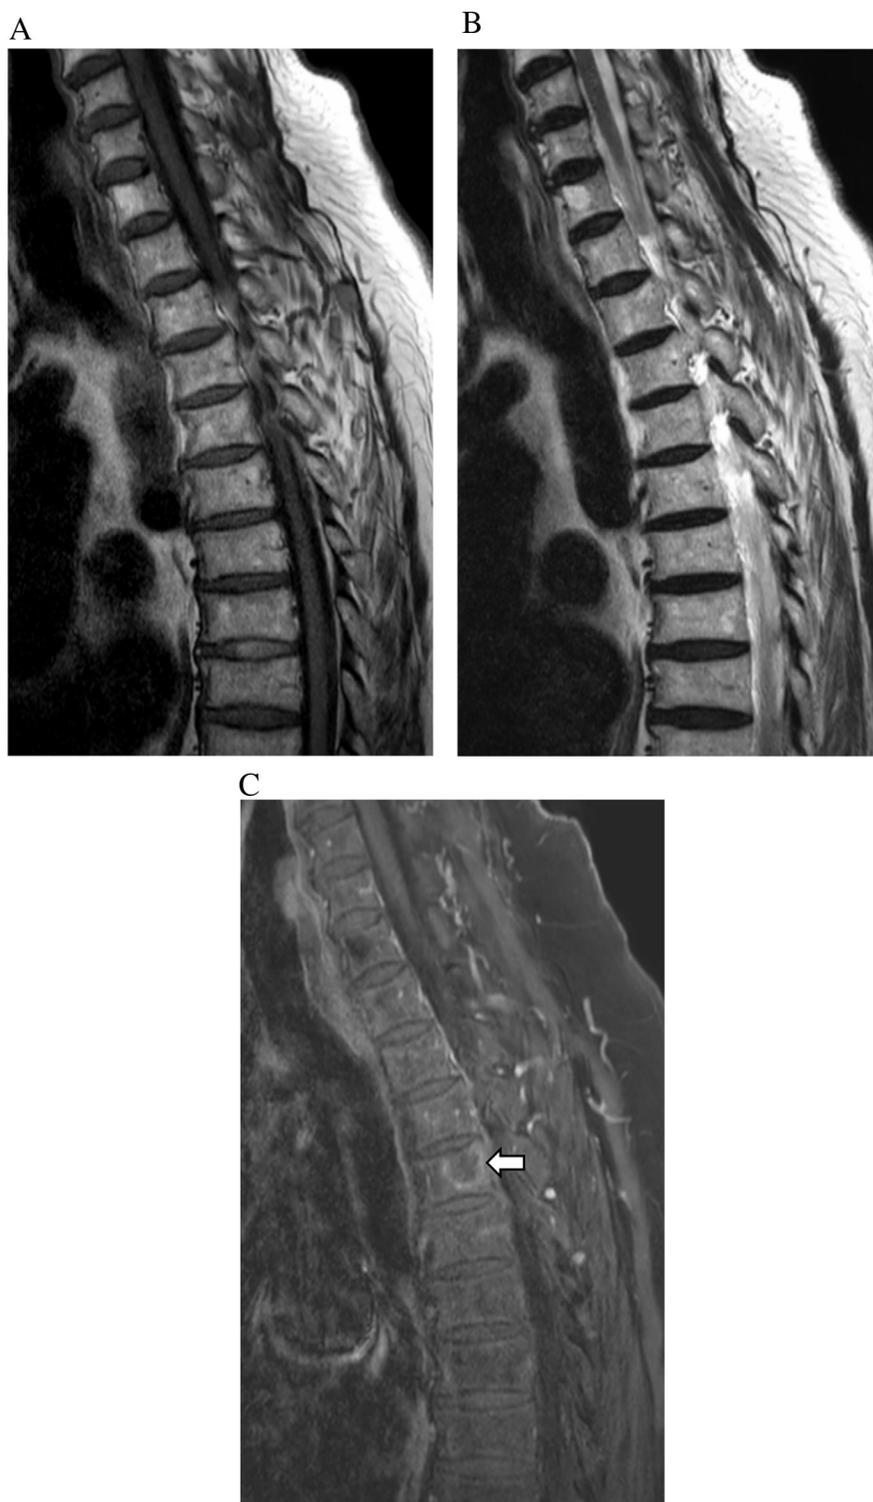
MR images in a 77-year-old man with colon cancer. A, B. Sagittal T1-weighted (A) and sagittal T2-weighted (B) turbo spin-echo MR images show no definite spinal metastasis. C. Sagittal fat-suppressed contrast-enhanced T1-weighted image shows a suspected metastatic mass with rim enhancement (arrow). Computed tomography-guided biopsy was performed, and the mass was confirmed as metastasis. None of the three readers could detect the metastasis during session 1 (reading of T1- and T2-weighted images), but all detected the metastasis during session 2 (reading contrast-enhanced images in addition to the conventional images). Reading category was classified as 6 (increased number of probably metastatic segments, no change of equivocal segments, and decreased number of probably benign segments during session 2, with reference to session 1; useful in detection of metastasis) and the degree of usefulness of the contrast-enhanced imaging was determined as definitely helpful. All three readers recorded the subjective overall usefulness as 2, the highest score.
